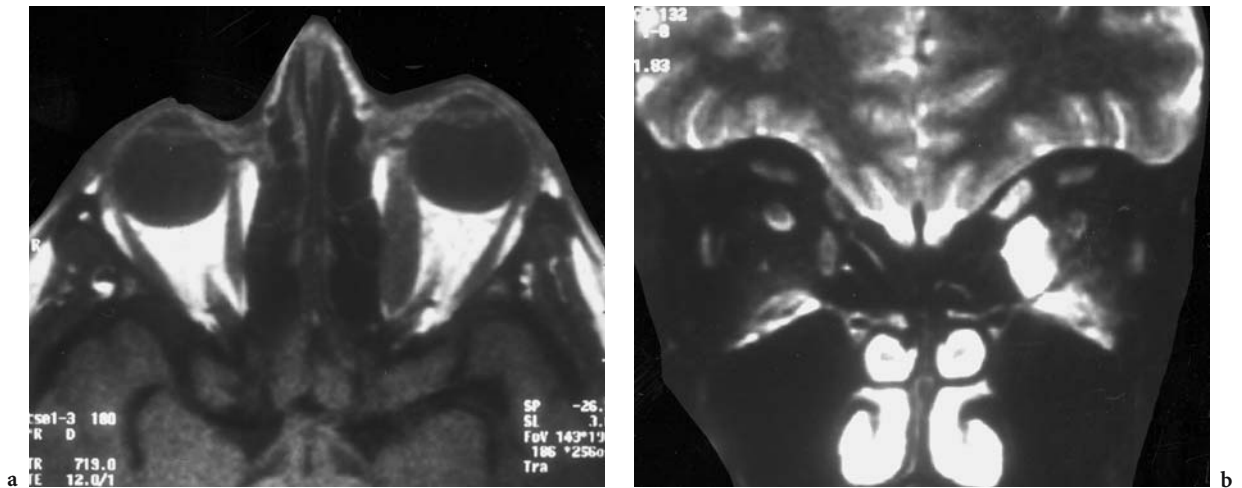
A 45-year-old woman with known hyperthyroidism, painless, left-sided proptosis, and incomplete abduction paralysis on the left side. Diagnosis: unilateral Graves' disease. MRI: a Axial T1-weighted view with enlargement of the left medial external muscle (although the tendon appears to be involved, Graves' disease was confirmed based on clinical symptoms and endocrinological findings; the patient profited from radiation therapy). b Coronal T2-weighted view with massive signal enhancement of the swollen inferior and medial left rectus muscles, representing intramuscular edema
